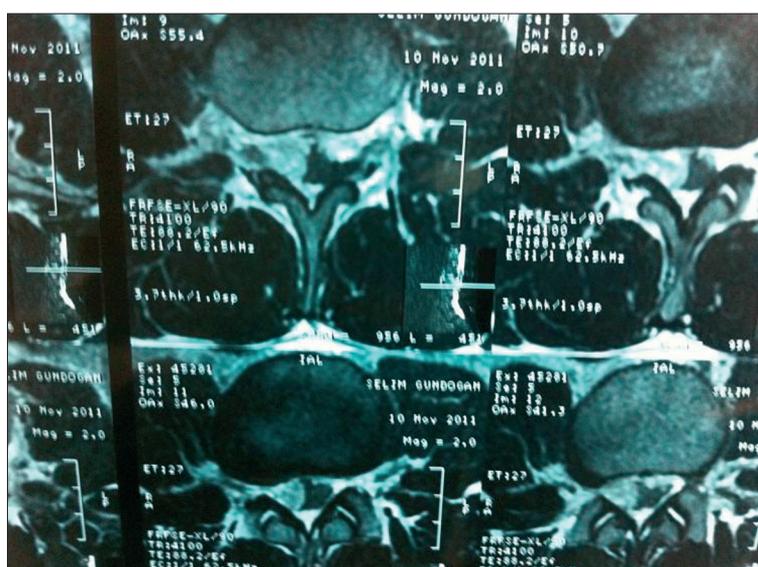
Initial axial T2 weighted MRI imaging of spinal epidural hematoma at L3.
